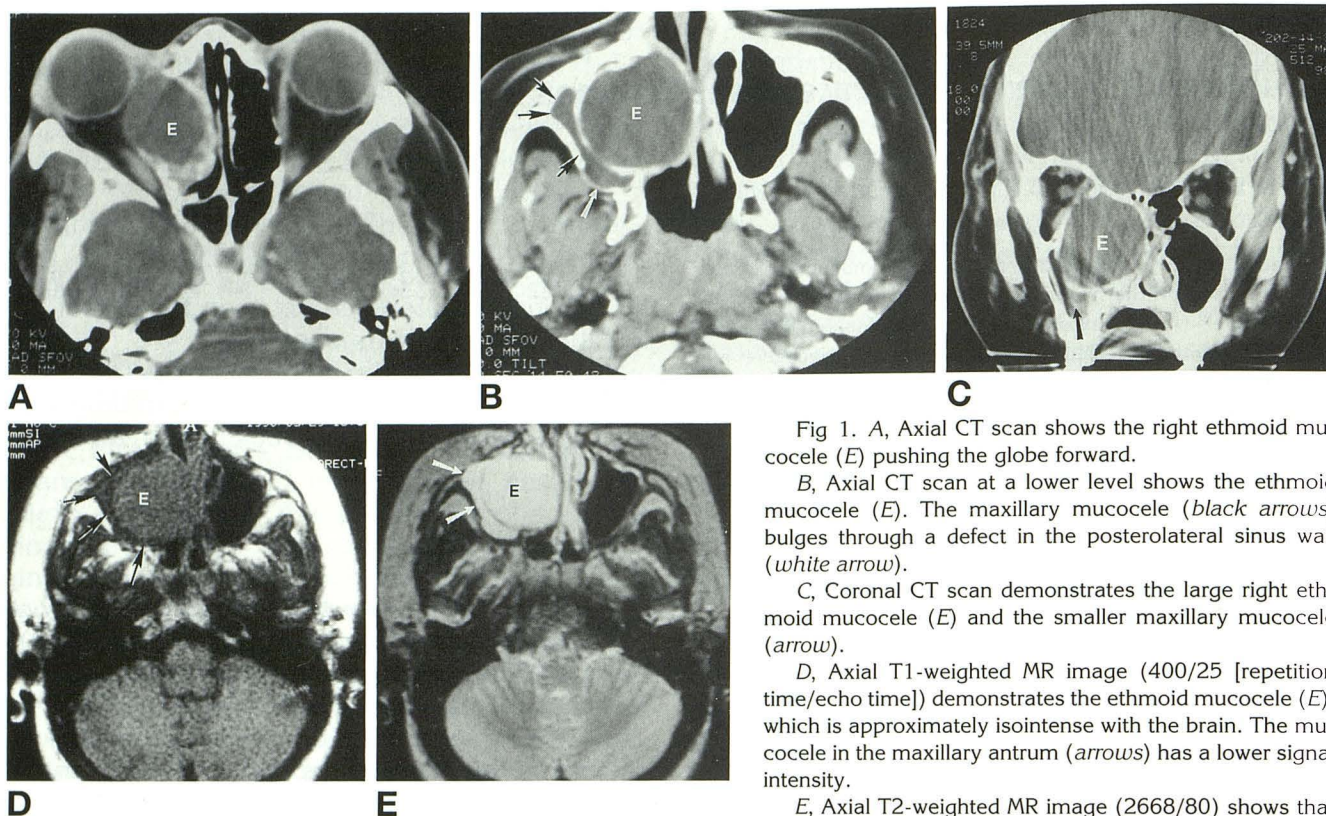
A, Axial CT scan shows the right ethmoid mucocele (E) pushing the globe forward.
